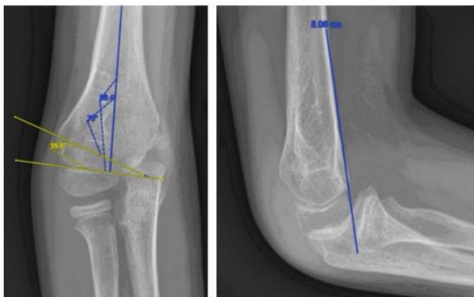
Plain radiographs showed Baumann angle of 86 degree and AHL does not pass through the capitellum.
